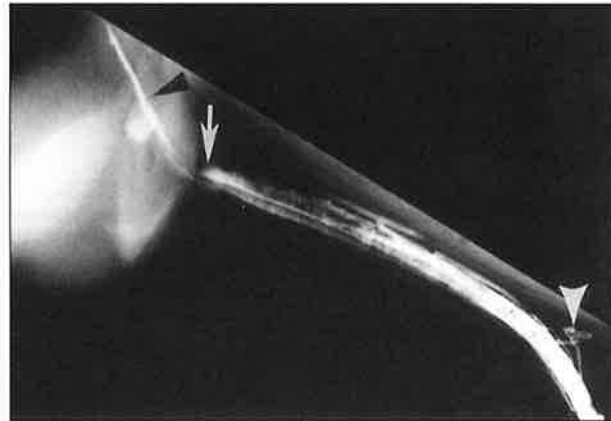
Lateral positive-contrast radiographic view of the corpus cavernosum penis (CCP). The distal portion of the CCP is filled with contrast medium to the vascular obstruction at the distal bend of the sigmoid flexure (white arrow). Leakage of contrast medium at the injection site due to back pressure (white arrowhead) produced a venogram (black arrowhead) extending proximal to the CCP blockage.
